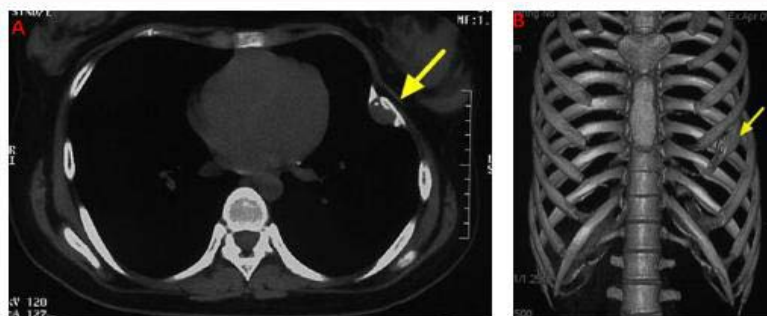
Computed tomography scans of chest. (A) A mass of 25 mm × 15 mm grew within the left fifth rib with the clear border; (B) A bone destruction occurred in the front of the left fifth rib, which seemed like a benign lesion.
